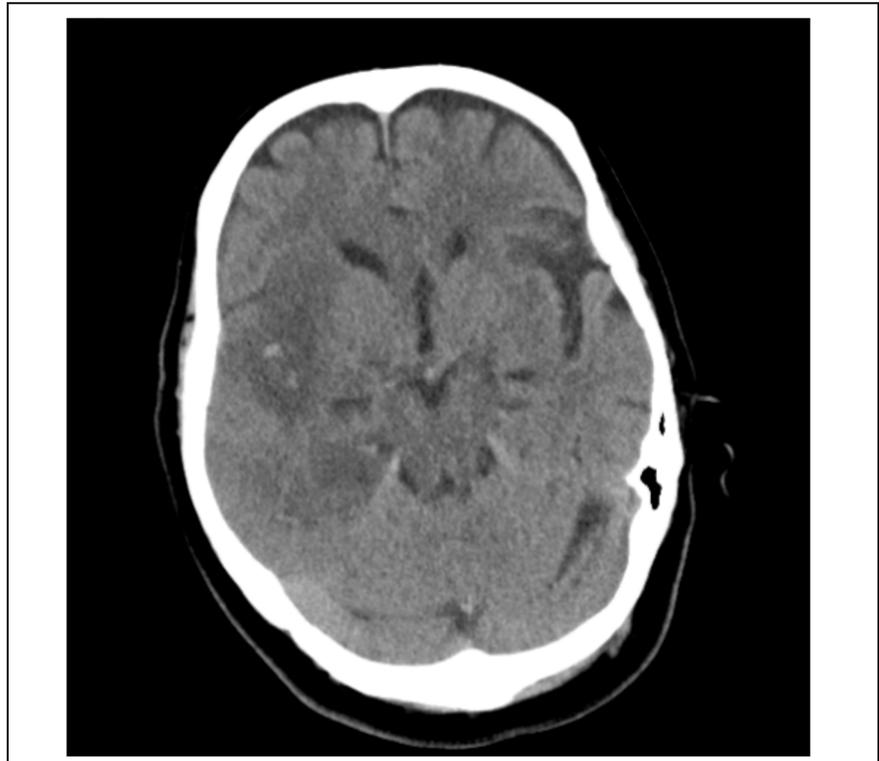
Simple axial computed tomography of the skull; with extensive hypodense area in the right temporal lobe with impaired differentiation, the rest of the brain structures have a normal densitometry characteristic. Asymmetric ventricular system with preserved capacity located in the middle. Free subarachnoid spaces. Bones-intact.
